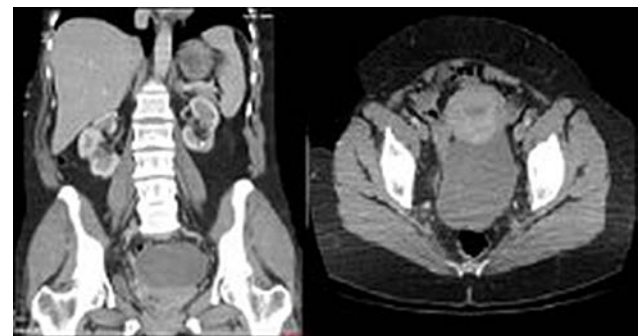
A CT scan of the abdomen and pelvis showing pelvic mass thought to arise from left ovary
